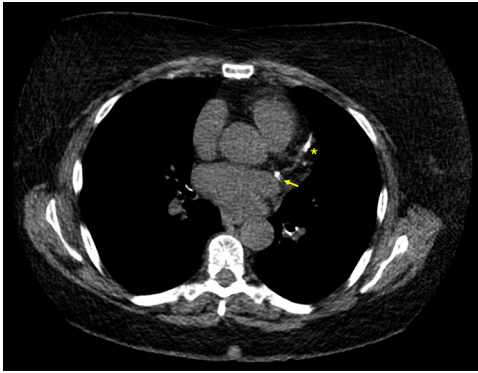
Coronary artery calcium scan. Non-contrast CT scan for coronary artery calcium detection and quantification demonstrating dense calcification in the proximal left circumflex (arrow) and mid left anterior descending (*) coronary arteries.
